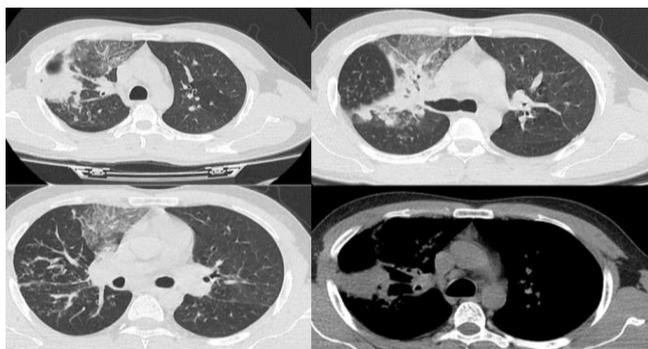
Peribronchial density increments notable in the right hilar area, adjacent to the right lung upper lobe minor fissure, while the ground glass area in the right upper lobe anterior has an appearance that creates peripheral consolidation on Chest CT
